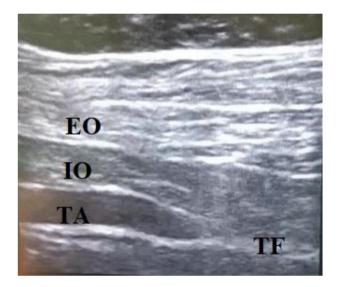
Ultrasound-guided transversalis fascia plane block. IO: internal oblique muscle, EO: external oblique muscle, Transversus abdominis muscle.
